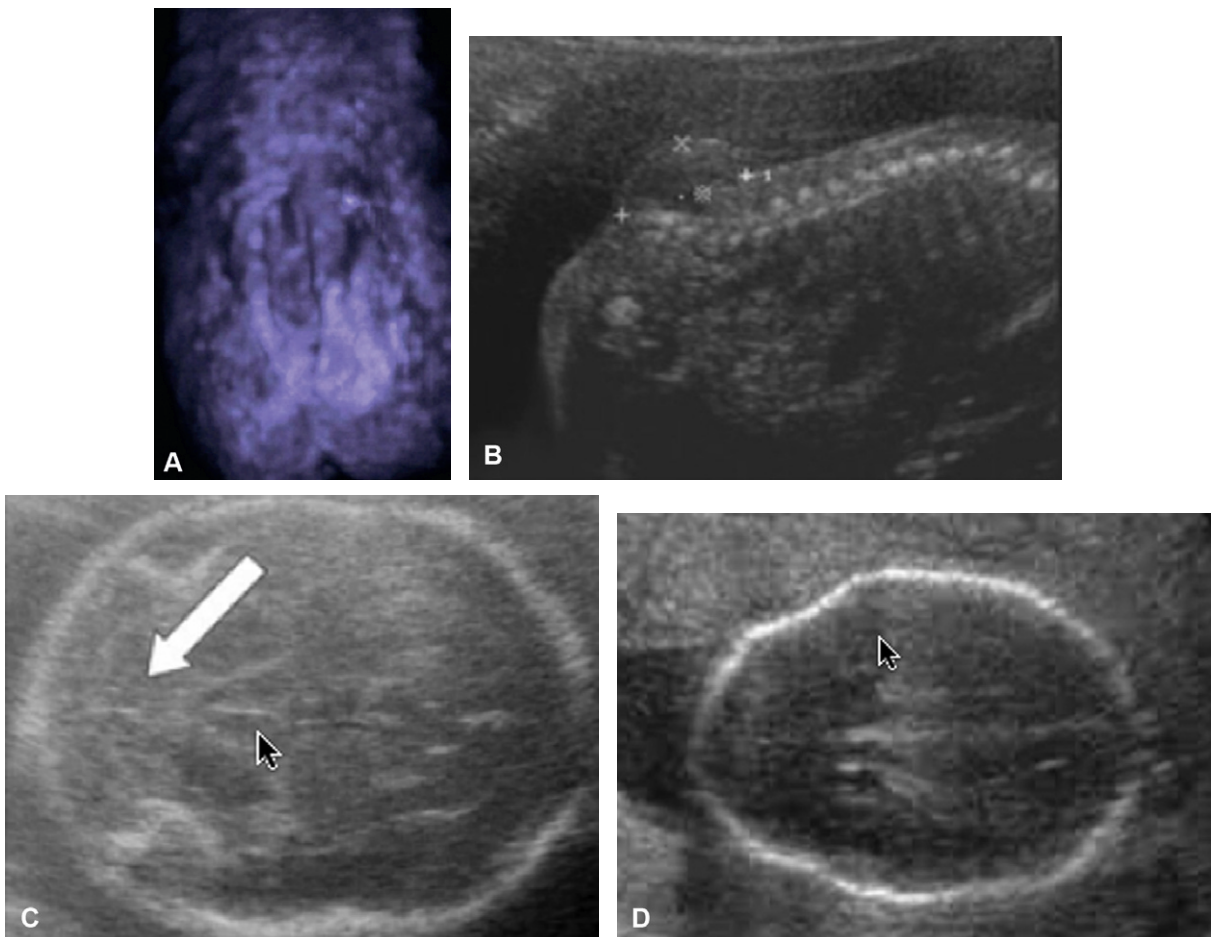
Myelomeningocele—antenatal diagnosis. (A) 3D ultrasound; (B) 2D ultrasound; (C) Chiari malformation (banana sign); (D) frontal narrowing (lemon sign).
